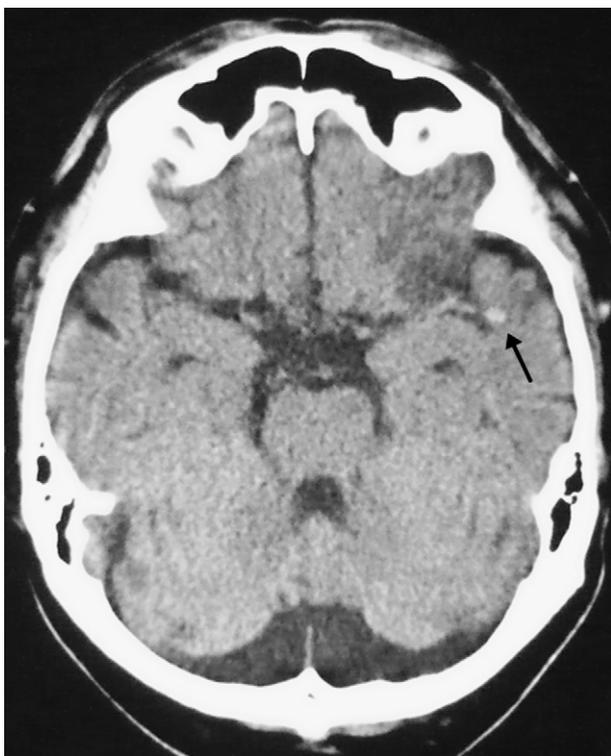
CT scan obtained the day after onset, showing cerebral infarction in the left frontal lobe and a persistent hyperdense nodule (arrow).
